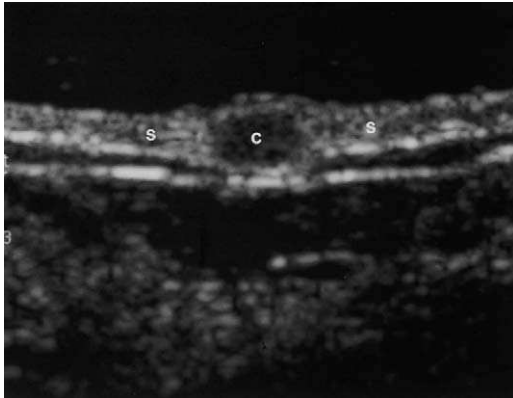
Sebaceous cyst. Ultrasound with standoff pad shows a hypoechoic lesion (c) with the skin layer (s) consistent with a sebaceous cyst.
